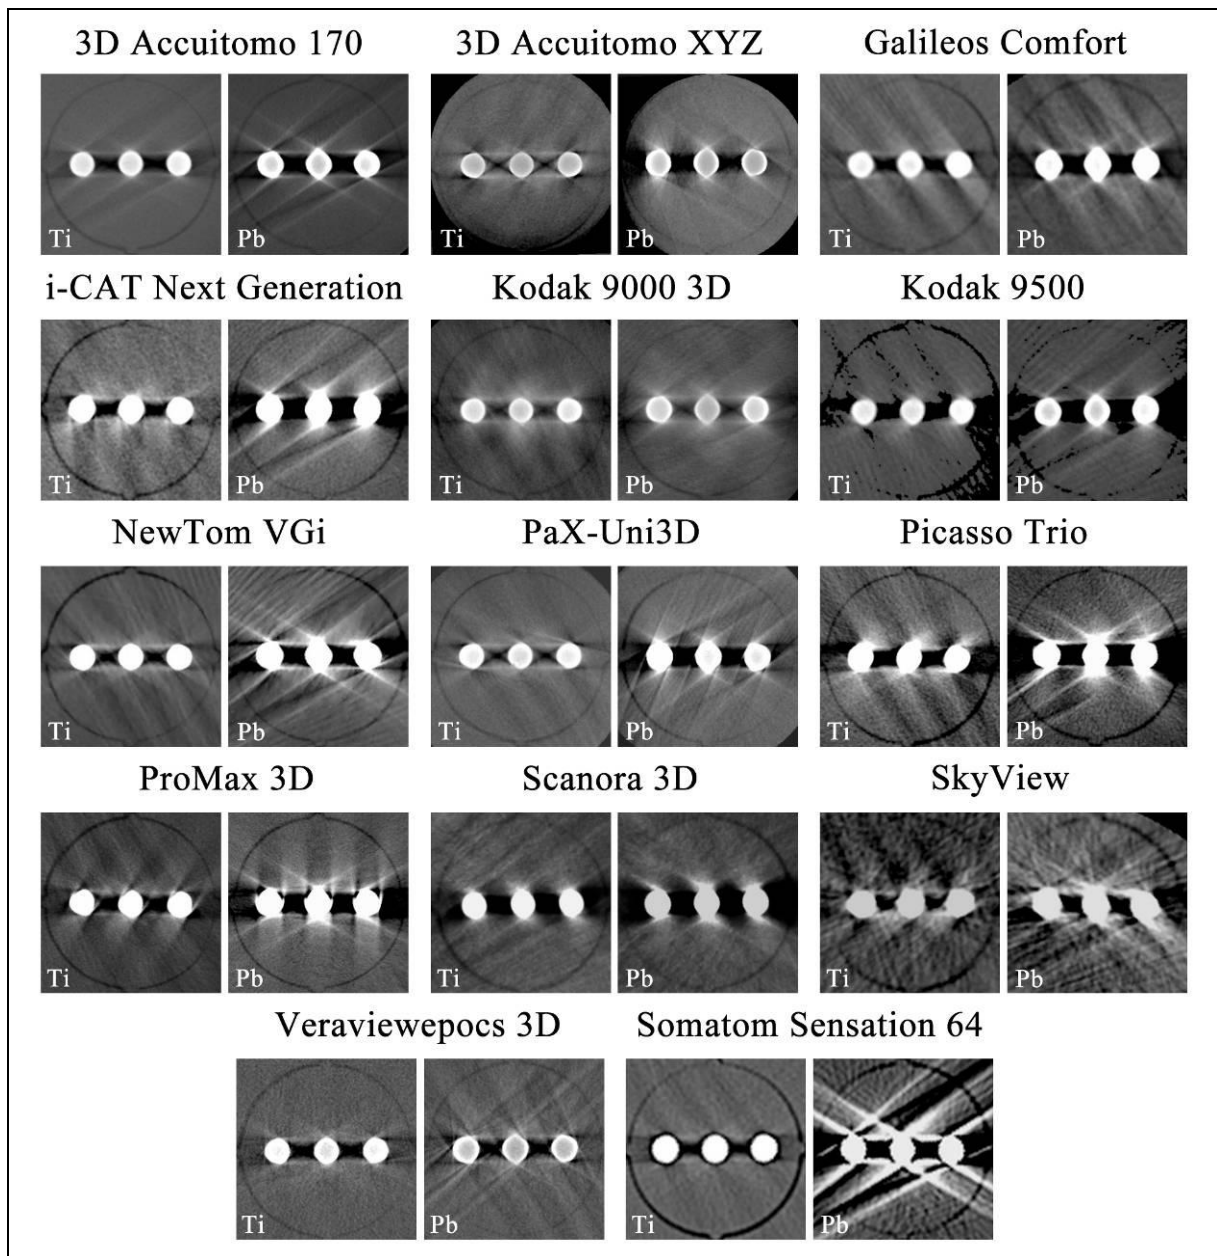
Axial slices of titanium and lead inserts for selected cone beam computed tomography and multi-slice computed tomography protocols. An automatic window/level setting was chosen in most cases; manual window/level adjustment was performed if the automatic setting was suboptimal. Visual evaluation of these artefacts should be avoided.
